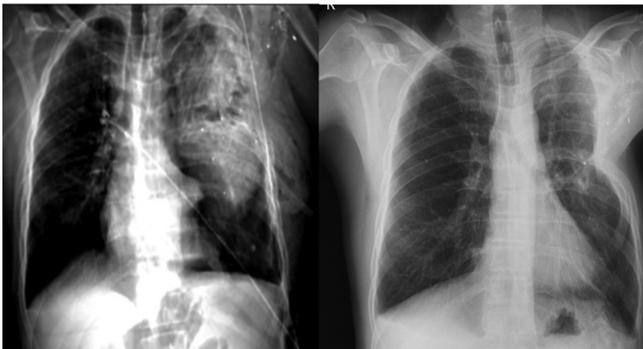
Posteroanterior chest X-ray on admission and 3 months after discharge
